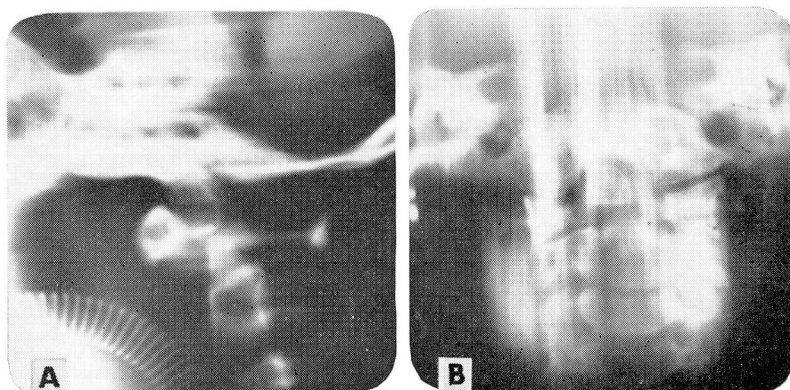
A, Roentgenogram of lateral cervical spine, showing forward displacement of os terminale. B, Roentgenogram of anterior cervical spine, showing os terminale.
